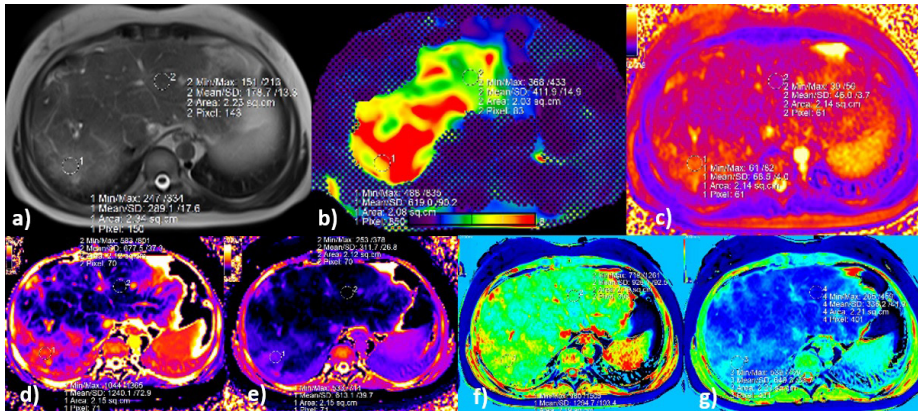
Magnetic resonance images acquired from a 32-year-old woman with occluded right and middle hepatic veins and a patent large left hepatic vein. (a) Axial T2-weighted image (T2WI), (b) color elastogram (confidence map), (c) T2 map, (d) pre-gadoxetic acid, and (e) post-gadoxetic acid T1 map acquired using the modified Look–Locker inversion (MOLLI) 3(2)3(2)5 sampling scheme, (f) pre-gadoxetic acid, and (g) post-gadoxetic acid B1-corrected variable flip angle (VFA) T1 map. All images were obtained at the same slice level. Regions of interest are drawn on the T2WIs (a) and copied and pasted onto the corresponding parametric maps (b–g).
